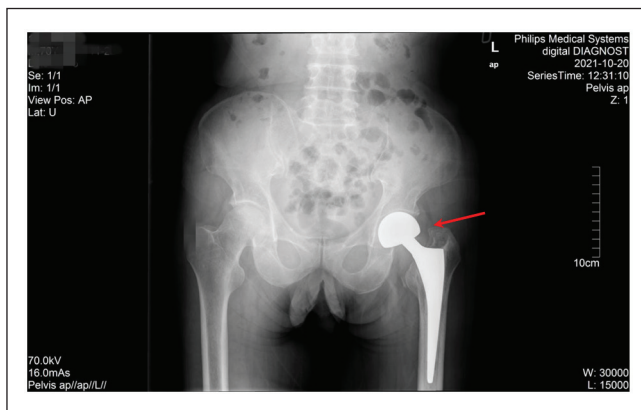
Anteroposterior radiograph of the pelvis on 20 October 2021. The left femoral head was surgically replaced (red arrow).
